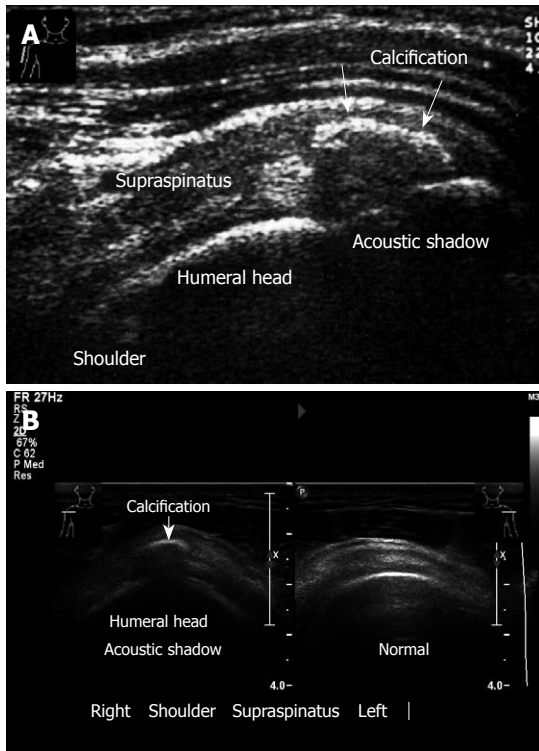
Shoulder calcification. A: Calcific tendinitis. Calcification in the supraspinatus tendon, longitudinal view. Note: Acoustic shadow behind the calcification. A 29-year old woman presents with a short history (3 d) of incapacitating shoulder pain and with severe restriction in the range of shoulder movement; B: Transverse sonogram. Calcification of supraspinatus, right. Left normal sonogram.
